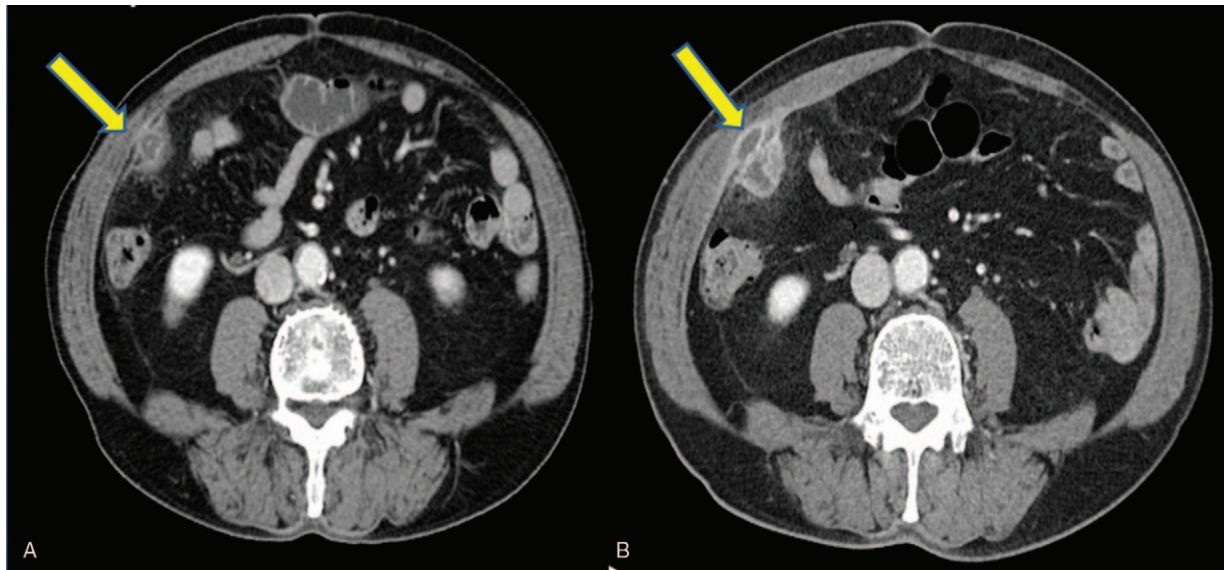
(A) Abdomen pelvic computed tomography view: small sized abscess formation (about 2.5 cm) abutting abdominal wall in right paracolic gutter (r/o parasite infestation). (B) Abdomen pelvic CT view after 2 weeks with antibiotics therapy: interval increased size of presumed abscess (about 4.5 cm) in right paracolic gutter with direct invasion of right anterior abdominal wall muscle.
